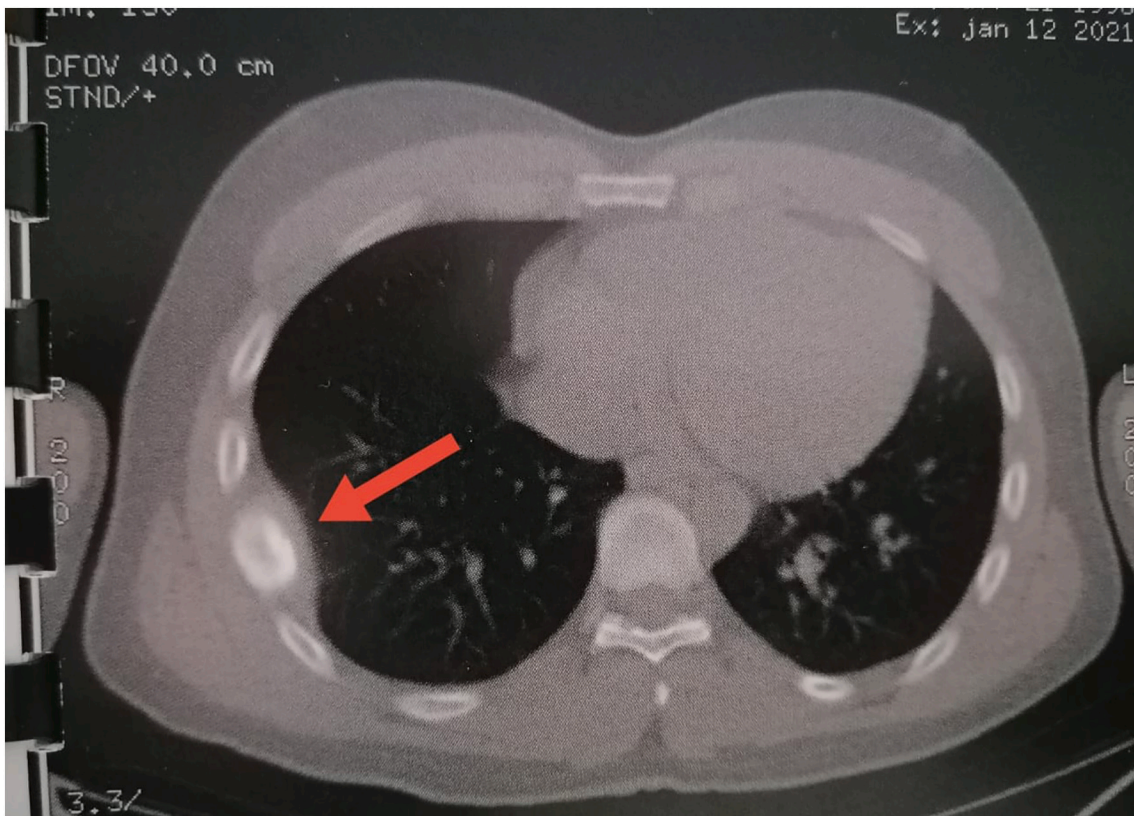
CT scan: osteocondensing lesion at the junction of the middle and posterior arches of the right 6th rib suggesting Ewing's sarcoma.
